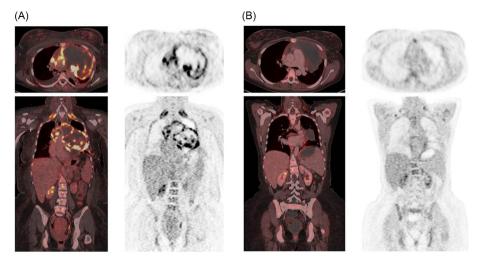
18F-FDG PET/CT imaging. A) Pre-treatment scan demonstrating a 16.4 × 11.2 cm mediastinal tumor mass with central necrotic areas and peripheral FDG enrichment. Obstruction and subtotal thrombosis of the superior vena cava and the left brachiccephalic vein, encasement of the aorta thoracica and subtotal compression atelectasis of the left lung lobe are shown. Pronounced signs of superior vena cava syndrome are evident with enlarged collateral venous vessels and pronounced liver congestion. B) Post-treatment response (Deauville 3). Reduction of mediastinal tumor mass and regression of subtotal thrombosis of the superior vena cava are evident.
